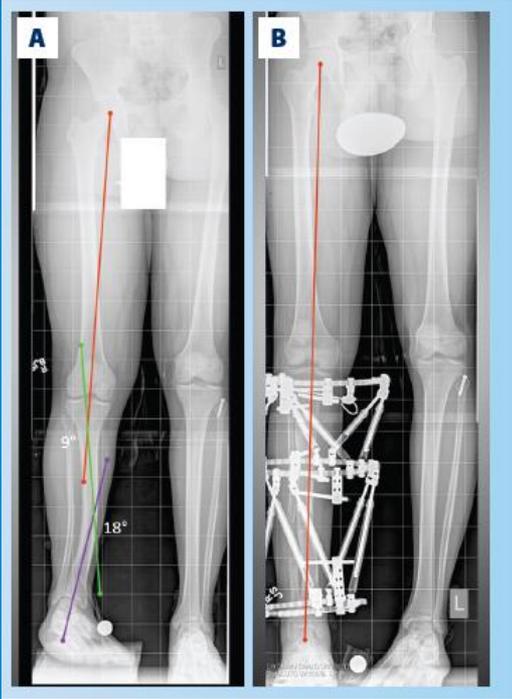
Standing AP radiograph of 17-year-old. Oblique plane posteromedial deformity of 19° (18° in coronal plane, 6° in sagittal plane), 9° proximal tibial varus deformity, and 7-cm LLD. B, Standing AP radiograph after double-level tibial deformity correction with hexapod external fixators.
